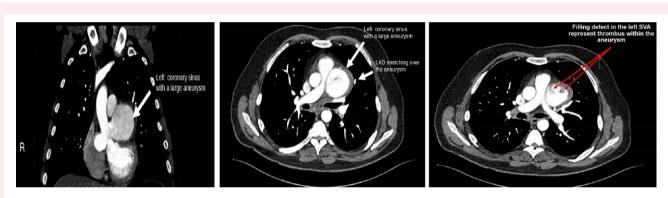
Contrast computed tomography showing hugely dilated left coronary sinuses in sagittal and horizontal plan, in addition to small thrombus at the left superior aspect of the aneurysm (red arrow).
